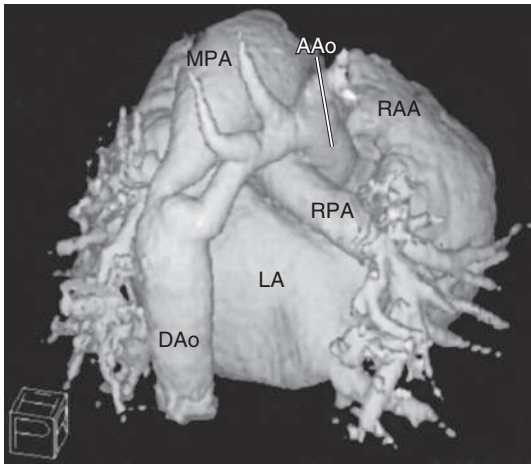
Three-dimensional reconstruction of CT images from a neonate with severe coarctation of the aorta. The patent ductus arteriosus can be seen toward the left leading from the main pulmonary artery to the descending aorta. The tortuous and narrow coarctated segment is just to the right of the ductus. The transverse aorta is hypoplastic as well. AAo, Ascending aorta; DAo, descending aorta; LA, left atrium; MPA, main pulmonary artery; RAA, right atrial appendage; RPA, right pulmonary artery. (Courtesy Dr. Paul Pitlick, Stanford University, Stanford, CA.)
